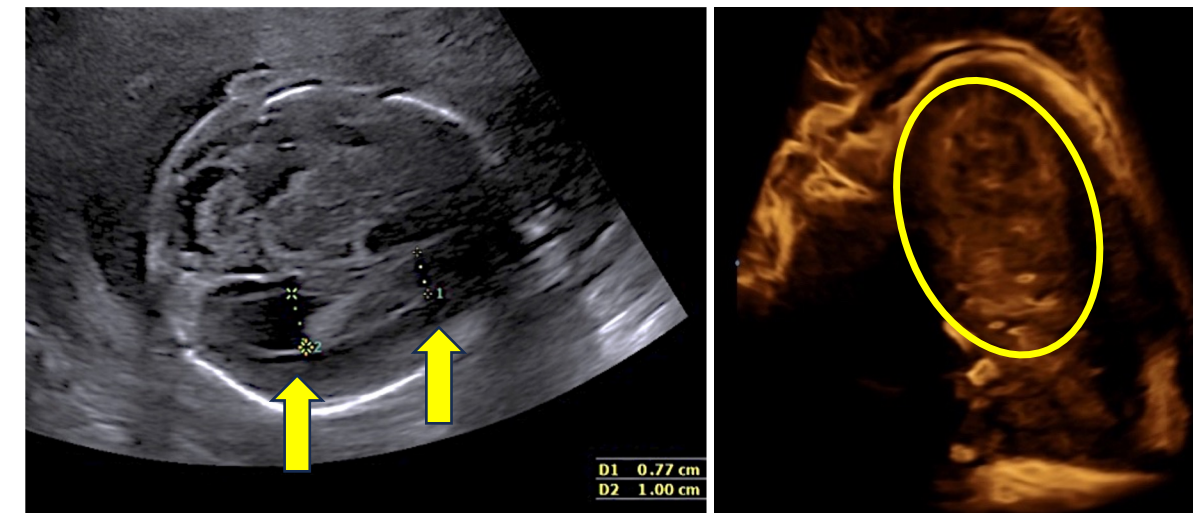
Targeted fetal cranial ultrasound. Axial view of the fetal cranium showing asymmetrical mild ventriculomegaly at 23 weeks. Figure 2B. A non-visualized corpus callosum-cavum septum pellucidum complex on midsagittal view at 30 weeks.
